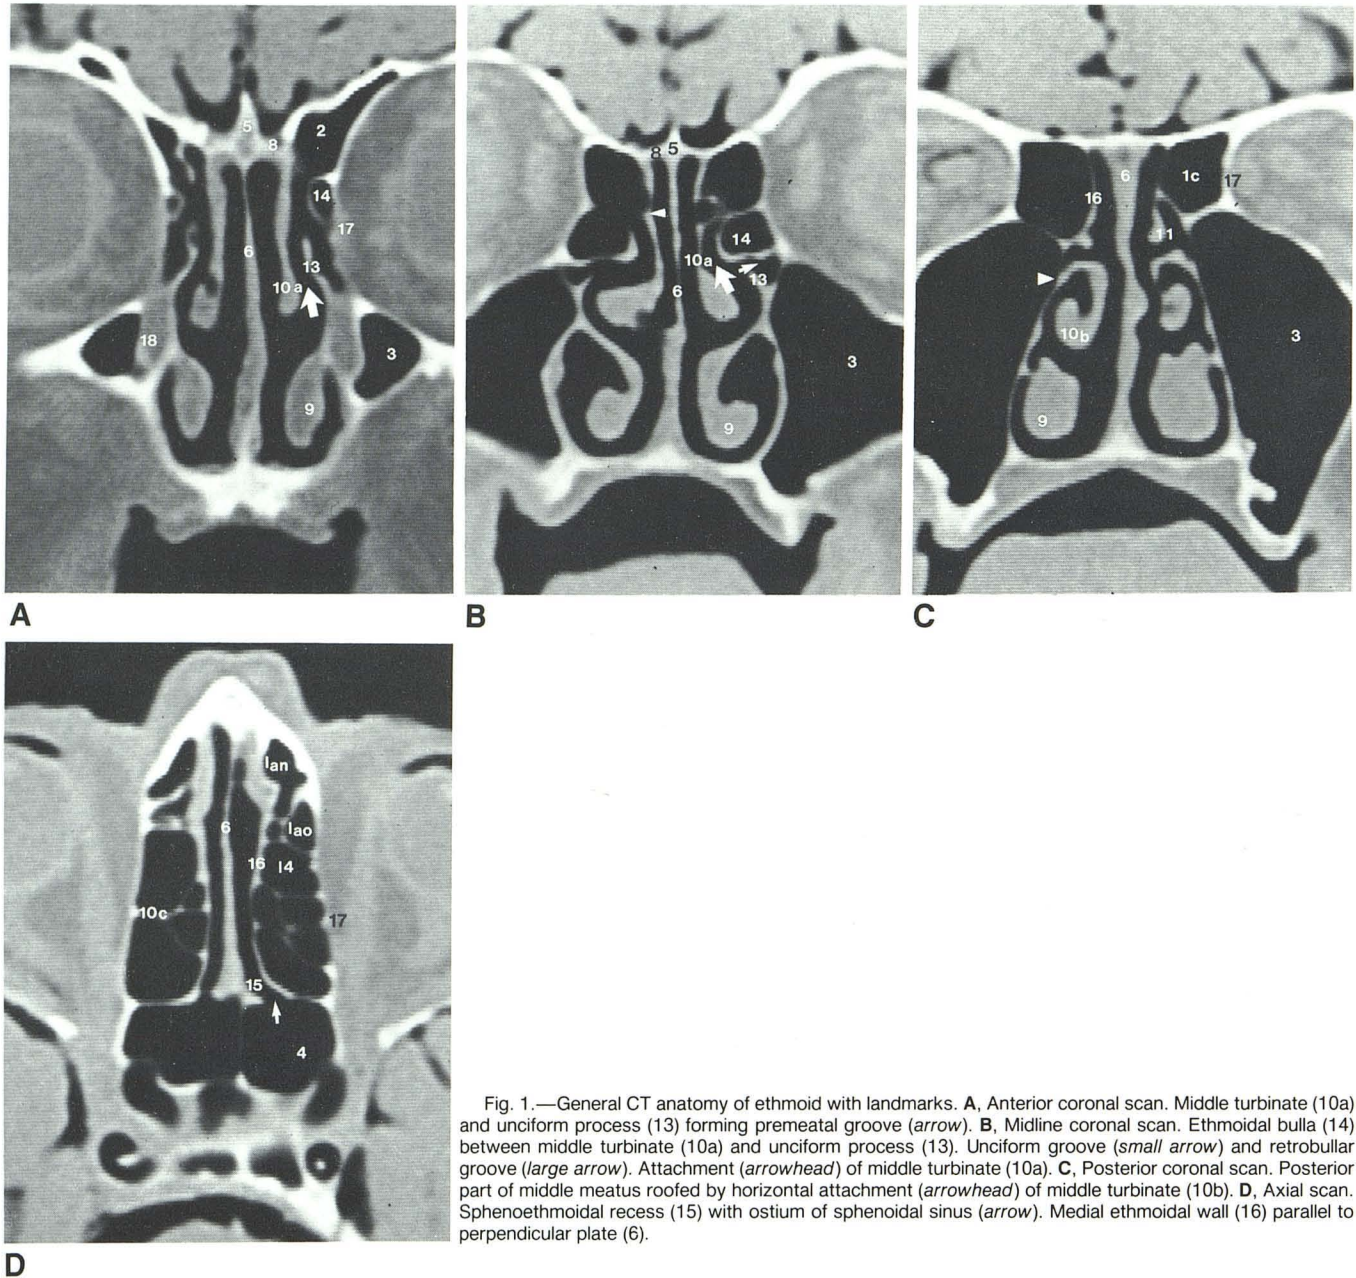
General CT anatomy of ethmoid with landmarks. A, Anterior coronal scan. Middle turbinate (10a) and unciform process (13) forming premeatal groove (*arrow*). B, Midline coronal scan. Ethmoidal bulla (14) between middle turbinate (10a) and unciform process (13). Unciform groove (*small arrow*) and retrobullar groove (*large arrow*). Attachment (*arrowhead*) of middle turbinate (10a). C, Posterior coronal scan. Posterior part of middle meatus roofed by horizontal attachment (*arrowhead*) of middle turbinate (10b). D, Axial scan. Sphenoidal recess (15) with ostium of sphenoidal sinus (*arrow*). Medial ethmoidal wall (16) parallel to perpendicular plate (6).
